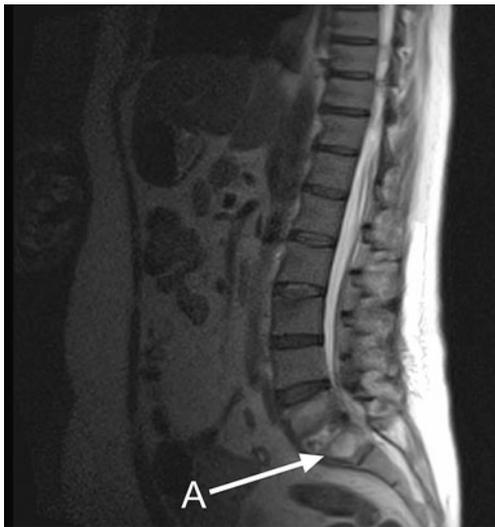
Sagittal section of magnetic resonance imaging. *A*, L5/S1 diskitis with an epidural abscess
